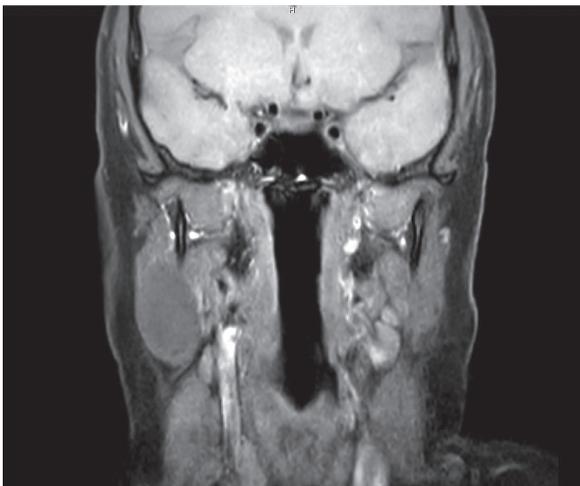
Coronal magnetic resonance imaging view of the lesion in T1.
